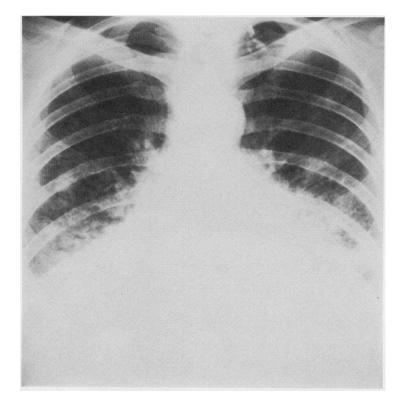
Postero-anterior radiograph showing diffuse and nodular bilateral infiltrates in the mid and lower zones.
